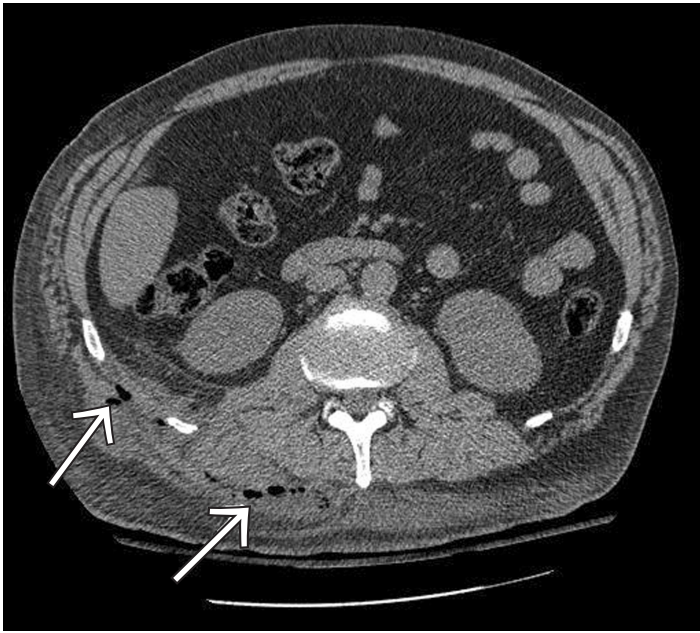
Computed tomography scan of the abdomen demonstrating gas (arrows) in the right paraspinal muscles.
